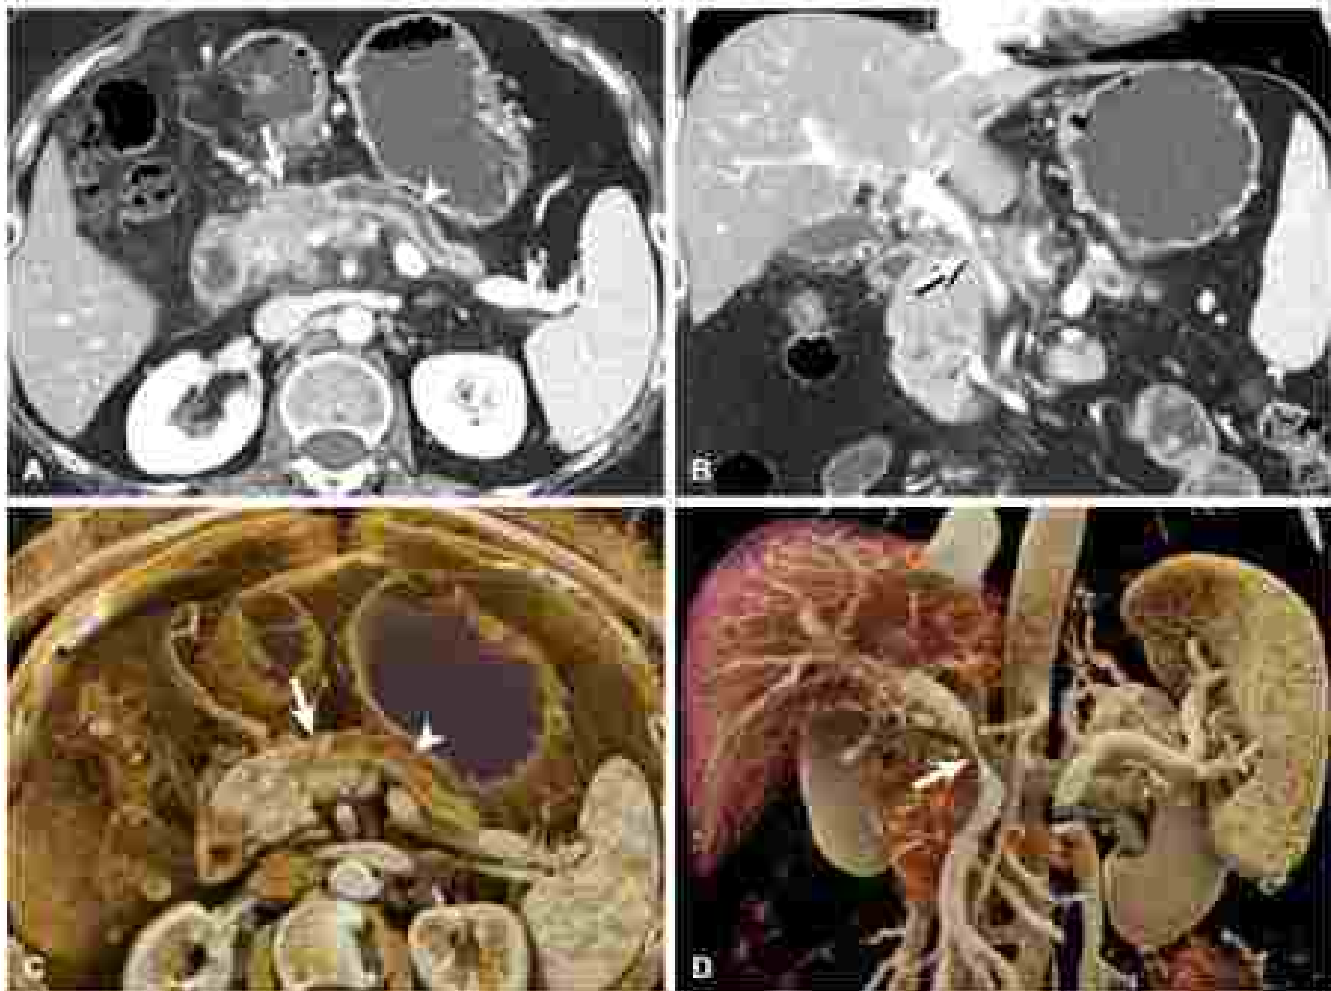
Pancreatic adenocarcinoma with assessment of the portal vein, superior mesenteric vein, and inferior vena cava. (A) Axial portal venous phase computed tomography image demonstrating an 6-cm-thick hypoattenuating mass in the pancreatic head (arrow) with slight caliber change of distal main pancreatic duct (arrowhead). (B) Coronal portal venous phase computed tomography image shows tumor encasement and severe narrowing of the portal vein, superior mesenteric vein, and inferior vena cava (arrows). (C) Oblique rendering of the pancreatic head mass (arrow) with distal main pancreatic duct (arrowhead). (D) Coronal rendering (axial location) of the distal of portal vein, superior mesenteric vein, and inferior vena cava, compared with (B) two-dimensional coronal reconstruction (portal vein (L), superior mesenteric vein (L), inferior vena cava (R)). Arrows indicate narrowing of pancreatic superior mesenteric and inferior vena cava (white arrow).
